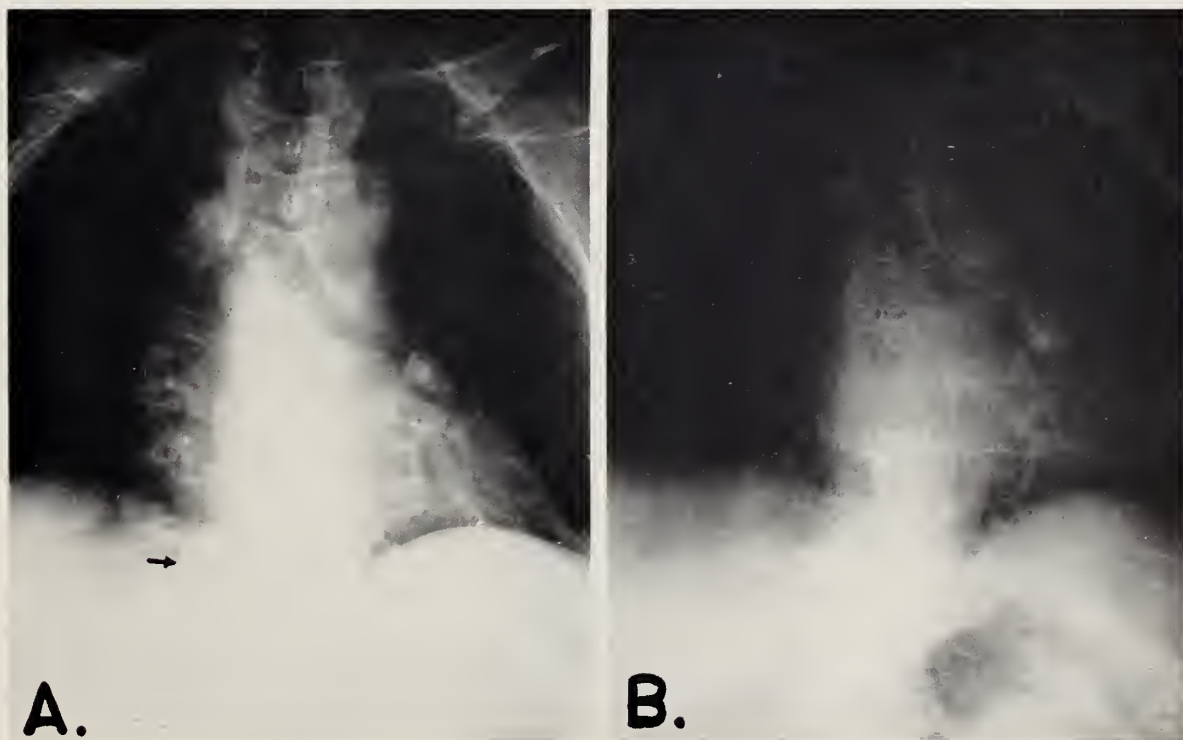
Roentgenograms of a patient with multiple myeloma treated with cyclophosphamide. *A*, film taken prior to cyclophosphamide therapy. The arrow points to a large paravertebral plasmacytoma. *B*, film taken after ten months of cyclophosphamide therapy. The plasmacytoma is no longer visualized. For discussion, see text.
